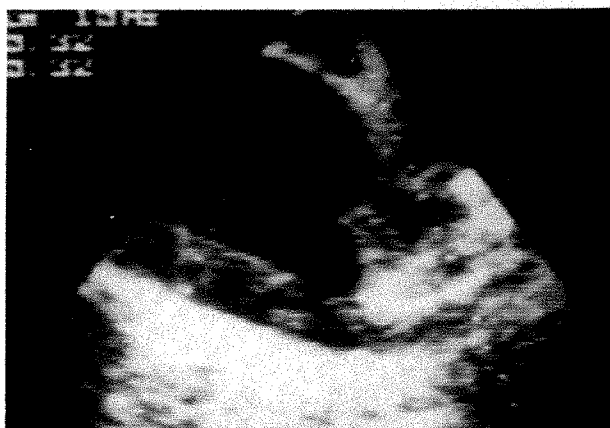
This 69-year-old woman affected by non-Hodgkin's lymphoma with a huge mediastinal mass was prospectively examined. Transesophageal echocardiography allowed recognition of the compression of the left pulmonary artery at its bifurcation.
